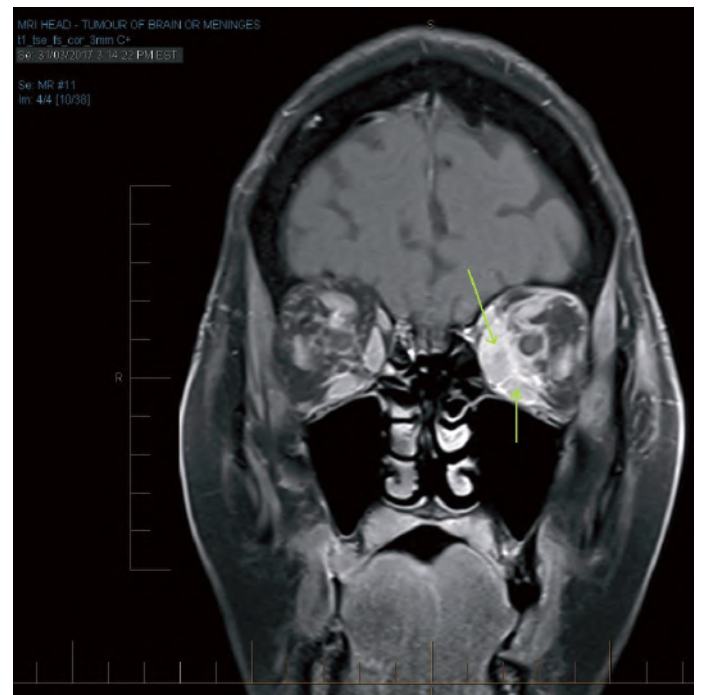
Coronal T1 fat suppressed MRI of the brain and orbits post radiotherapy showing persistent bilateral orbital inflammatory process (L>R). Marked swelling of the left medial and inferior recti is seen.
